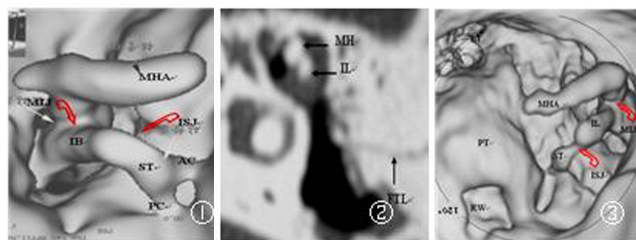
Virtual CT otoscopy (VE) of the normal right ear.
